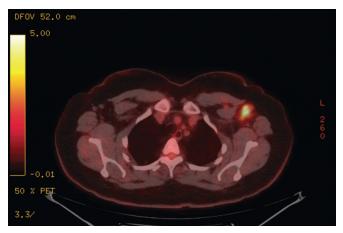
Figure G-3 Axial PET/CT slice of a patient with a left breast cancer that involved the level I axilla and Rotter's lymph nodes. The level I adenopathy is located lateral to the pectoralis minor muscle, and the involved Rotter's lymph nodes are anterior to the pectoralis minor muscle and posterior to the pectoralis major muscle. *CT*, computed tomography; *PET*, positron emission tomography.
